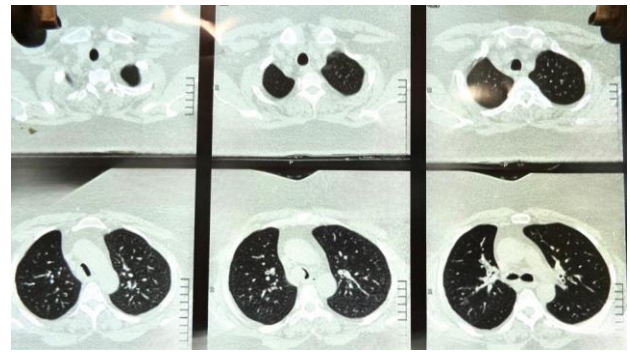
CT scan chest shows- Tumor in the lower trachea. Visually upper trachea and carina are normal.
